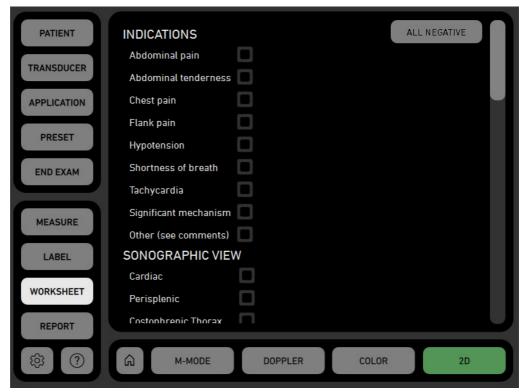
Worksheet showing Indications and Sonographic View.
